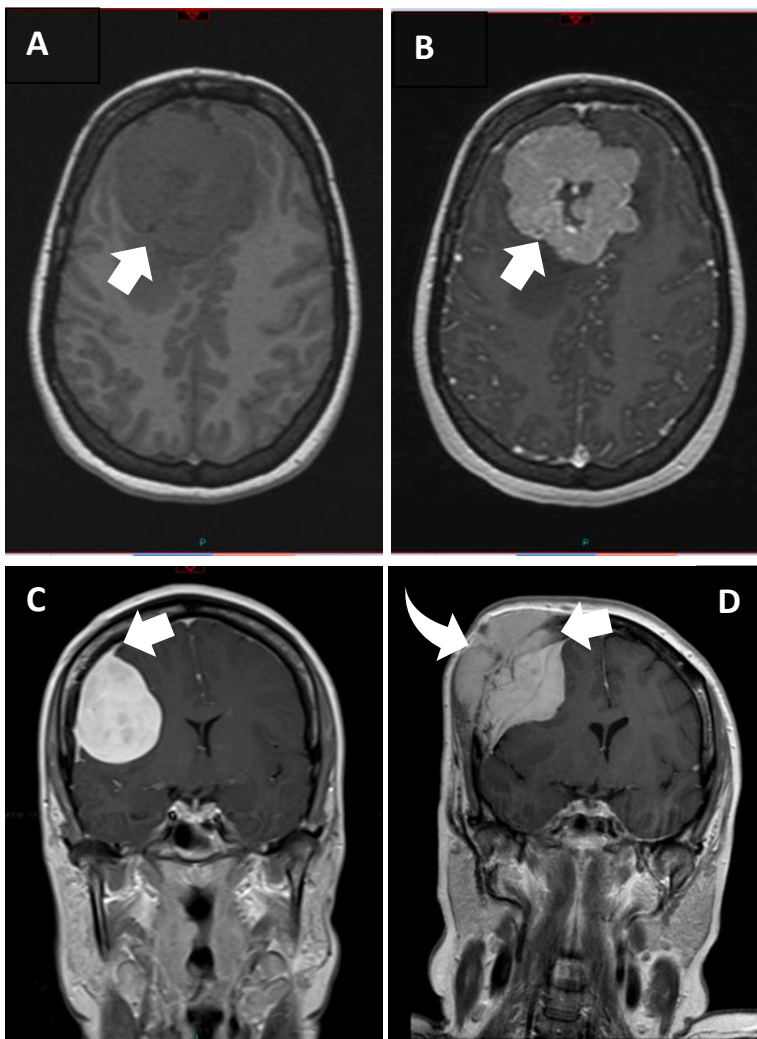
MR brain scans of various intracranial meningiomas. (A) and (B) Axial gadolinium enhanced pre and post contrast T1 sequence demonstrating an anterior cranial fossa meningioma before (A) and after (B) administration of gadolinium contrast (white arrows). (C) A coronal T1-weighted MRI showing Right sided convexity meningioma with enhancement of the 'dural tail' (white arrow). (D) Coronal gadolinium enhanced post contrast T1 sequence MRI demonstrating right sided intraosseous meningioma. There is hyperostosis (straight white arrow) and bone invasion (curved white arrow).
